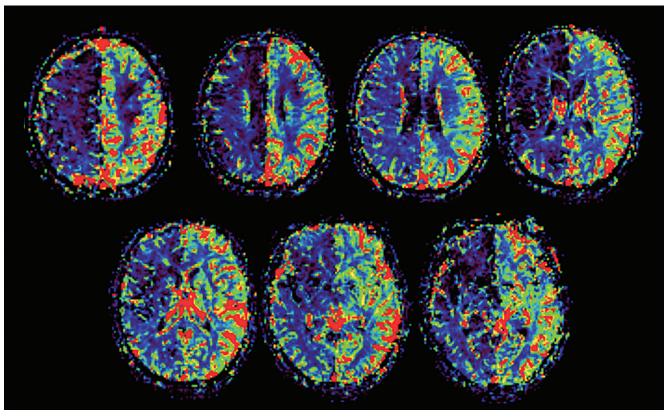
Axial MRI perfusion images of cerebral blood flow show substantially increased perfusion in the left cerebral hemisphere attributable to luxury perfusion.
